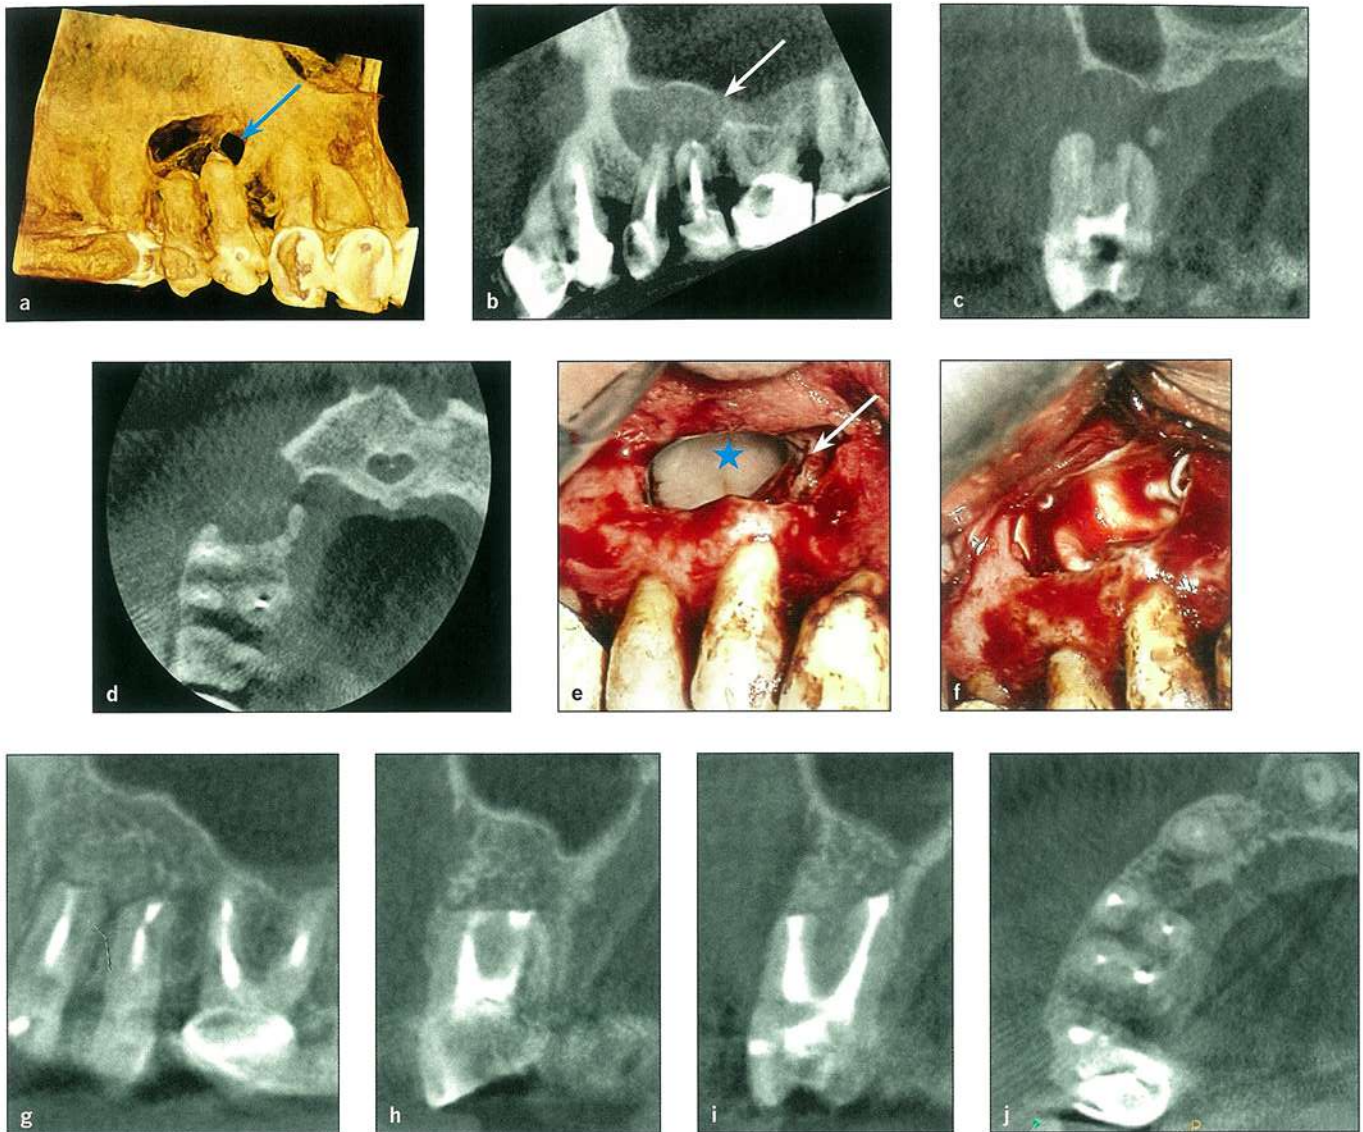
(a) CBCT 3D rendering of maxillary right premolars referred for periapical microsurgery. Perforation of the maxillary sinus can be visualized (*blue arrow*). (b) Sagittal view of the premolars. Perforation of the maxillary sinus is noted (*white arrow*). (c) Coronal view of the first premolar demonstrating the through-and-through nature of the periapical defect. (d) Axial view demonstrating the mesiodistal extent of the periapical defect. (e) Clinical image demonstrating the large maxillary sinus communication, vasculature (*blue star*), and the maxillary sinus septa (*white arrow*) that will be utilized to hold the absorbable membrane. (f) CopiOs membrane placed prior to the placement of Infuse bone morphogenetic proteins (Medtronic) and bone grafting with an enCore combination. (g to j) Two-year postoperative CBCT images of the premolars demonstrating bone remodeling observed in the sagittal view (g), coronal view of the first premolar (h), coronal view of the second premolar (i), and axial CBCT view (j). Both buccal and palatal cortical plate remodeling can be observed.
